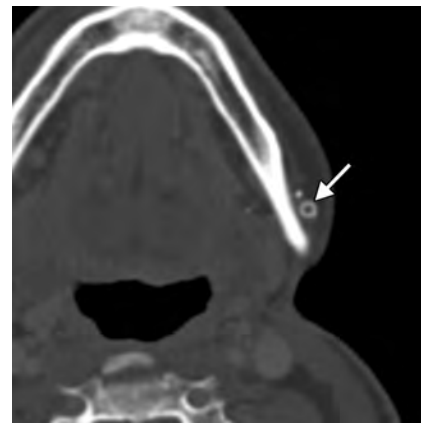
Gracilis free flap. Axial CT image shows a hyperattenuated circular ring connector (arrow) used to facilitate the vascular anastomosis.
